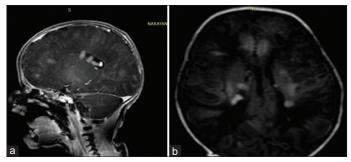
(a) 3T Magnetic resonance imaging brain-multiple foci of cortical thickening in cerebral hemispheres on both sides with periventricular nodule consistent with tuberous sclerosis and (b) Electroencephalography-Electrographic seizures of right frontal region
